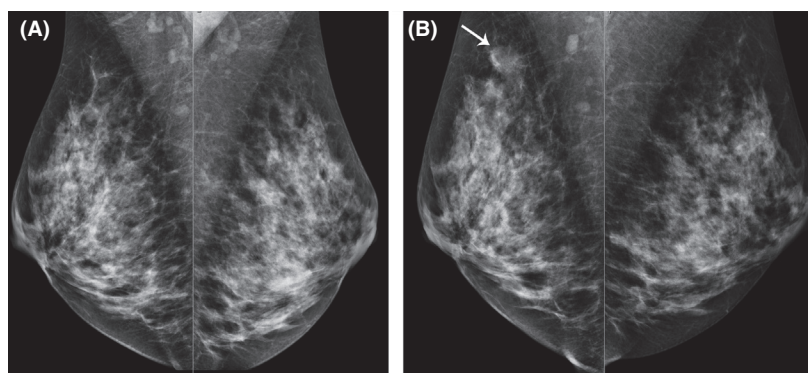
Bilateral oblique mammograms: (A) 2013 and (B) 2014. This 36-year-old BRCA 1 mutation carrier presented with a palpable mass in the upper outer quadrant of the right breast 9 months after a normal screening mammogram (A). MRI at this time was also normal. The repeat mammogram (B) shows a 25 mm poorly defined area of asymmetric density containing pleomorphic microcalcifications (arrow). A normal sized but dense lymph node is also noted in the right axilla.
